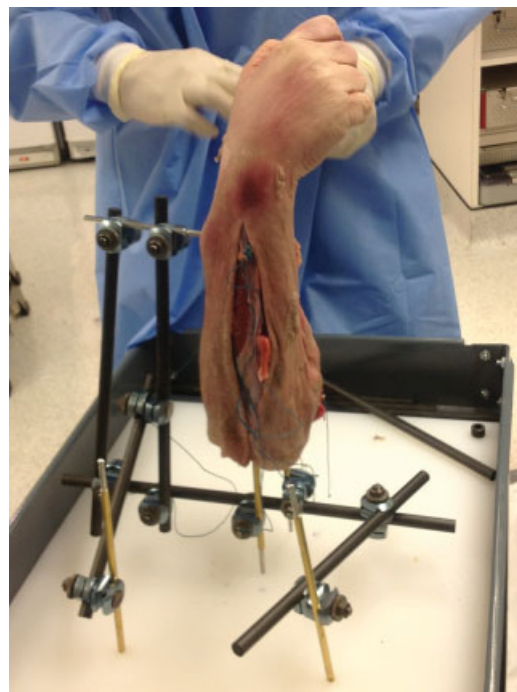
External fixator used for suspension of weights to allow positioning of wrist during radiographs. External fixator bars are secured to threaded pins inside the customized testing cart. The suture loops (attached to the forearm tendons) were passed through drill holes at the base of the white testing platform. Not pictured: Small metal hooks were attached to the suture loops, allowing the application of weighted plates to the forearm tendons.
